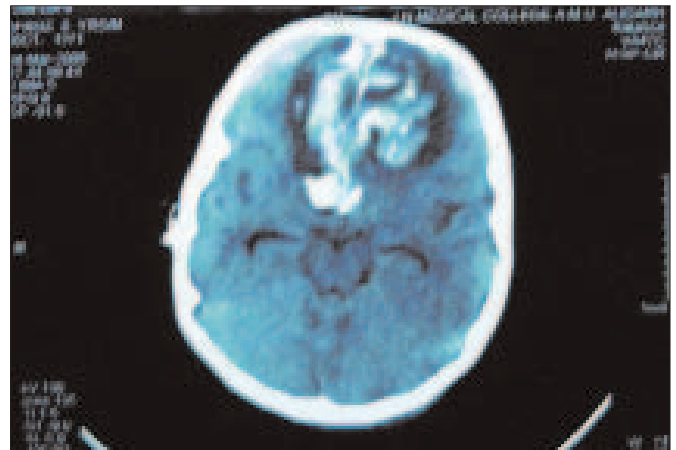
Non-contrast CT scan of the brain showing intraparenchymal bleed in bilateral frontal regions with perilesional oedema.
